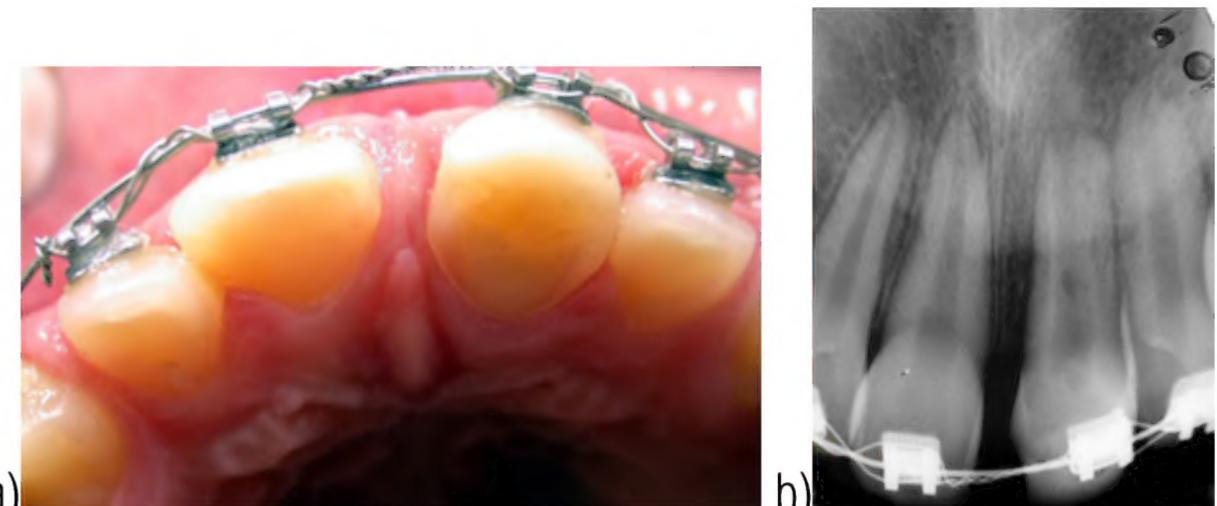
a) Six months follow-up; b) periapical radiograph.
